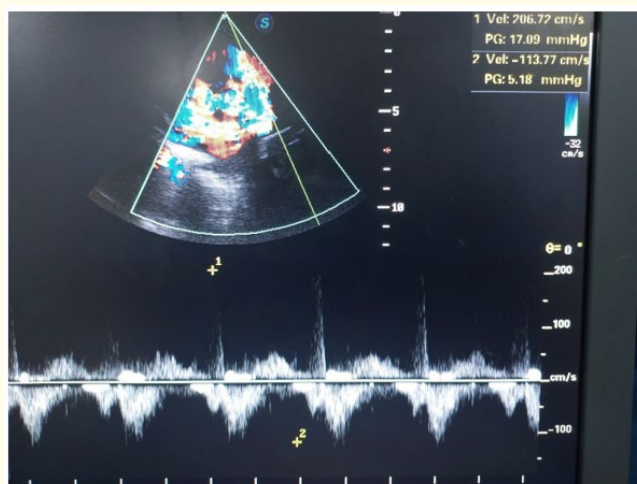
2D-echocardiography short axis parasternal CW doppler shows pulmonary regurgitation.
